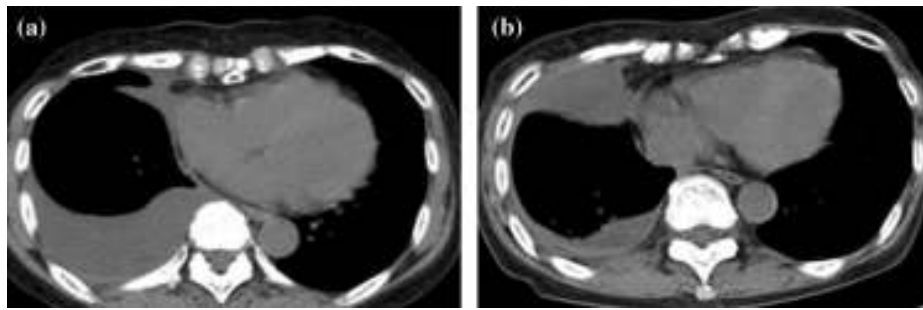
A 45-year-old man with persistent benign pleural effusions from chronic renal failure and alcoholic cirrhosis which were uncontrolled medically. A Axial CT images demonstrate right pleural effusion and passive atelectasis. No pleural nodules or evidence of malignant disease is identified. b One month after talc pleurodesis, the right pleural effusion has substantially decreased. A curvilinear high attenuation area can now be seen in the posterior pleura.
